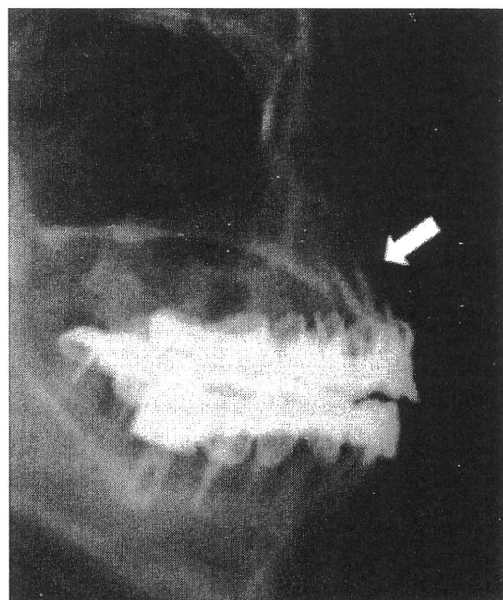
Radiography showed a maxillary bone defect around the implants (arrow).
